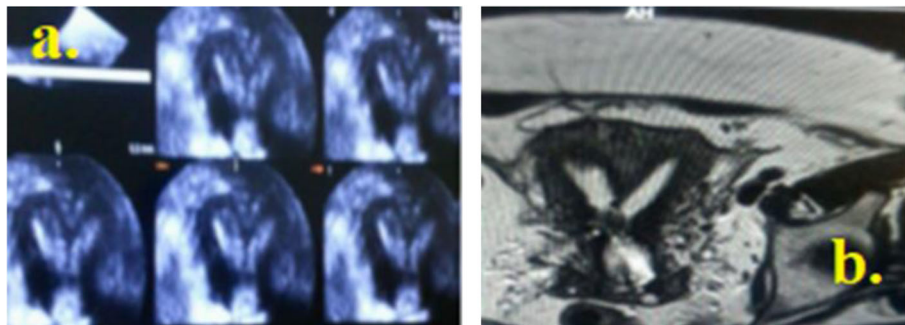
A 40-year-old married female patient complaining of recurrent abortions. a Partial septate (class U2A) by 3D TVS showing fundal indentation  $>50\%$  of uterine wall thickness. b MRI coronal T2 showing areas of low signal causing fundal indentation. c Multiple focal myometrial lesions, fibroids. Class U0 according to MRI findings
